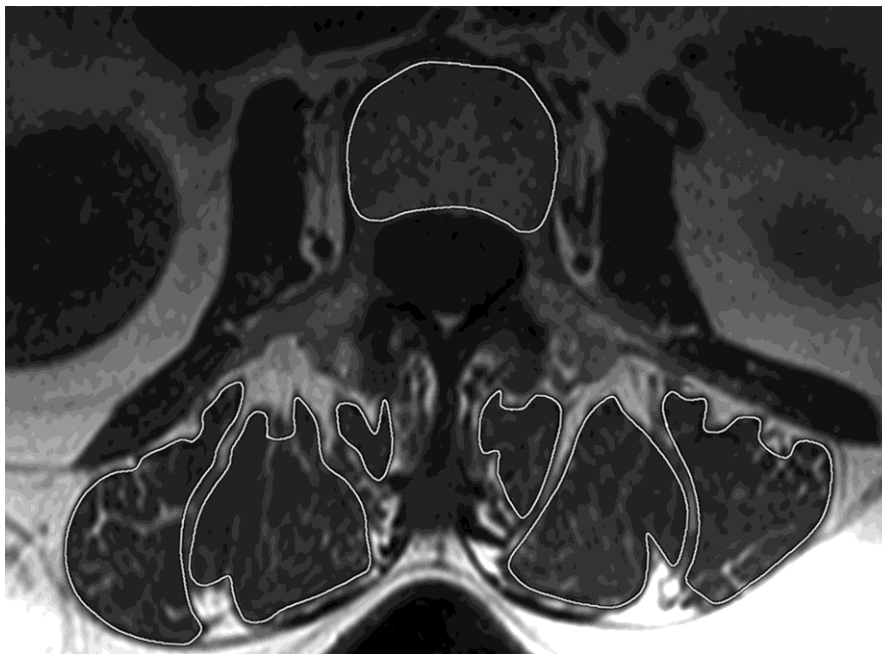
T1-weighted (578/12) axial image showing a manually drawn ROI positioned just within the cortical margins of the L3 vertebral body and the individual components of the erector spinae muscle for time intensity data-points measured from dynamic contrast-enhanced images. Individual components of erector spinae are spinalis, longissimus and iliocostalis from medial to lateral.
